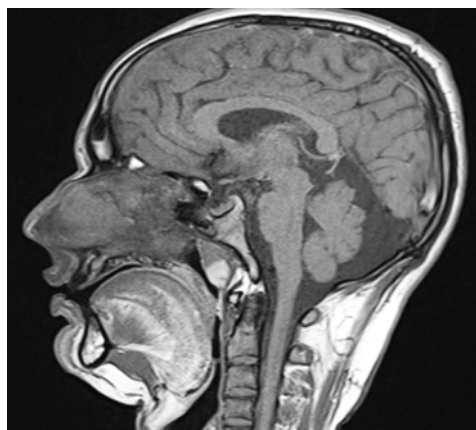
MRI of skull & skull base in sagittal section showing Tornwaldt's cyst.
